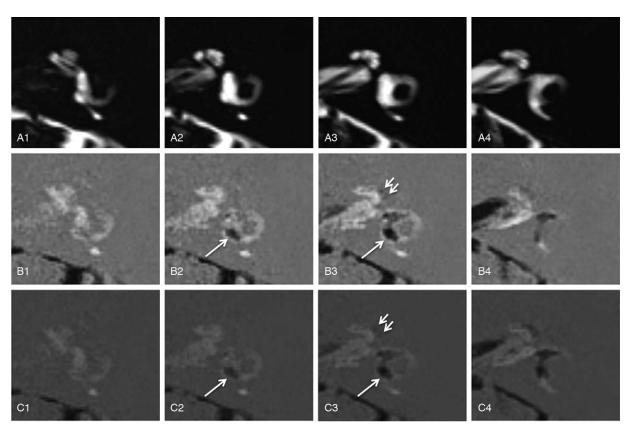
Representative images of dilatation of the endolymphatic space in the ampulla of the posterior semicircular canal (SCC). *A*, T2-weighted magnetic resonance cisternography is used to evaluate the anatomy of all fluid-filled labyrinth spaces. This image shows the regular anatomy of the vestibule and lateral SCC. *B*, T2-weighted three-dimensional fluid attenuated inversion recovery (3D-FLAIR) is used to visualize endolymphatic hydrops (EH). *C*, Hybrid of reversed image of positive endolymph signal and native image of positive perilymph signal (HYDROPS) is used to identify EH more clearly than T2-weighted 3D-FLAIR. Dilatation of the endolymphatic space in the ampulla is observed in the posterior SCC (black area in B2, C2, B3, and C3, the long *arrow*), but no vestibular EH is detected in (*B*) and (*C*). The short *arrows* show significant cochlear EH in B3 and C3.
